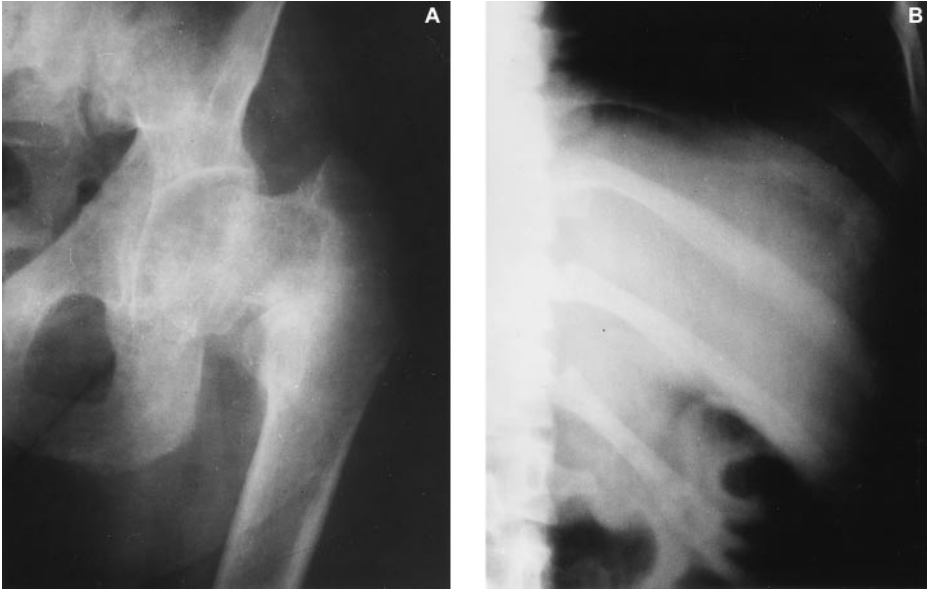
Adult-onset familial vitamin-D resistant hypophosphataemic osteomalacia. X-rays of a fracture of the left hip (A) and pseudofractures of the ribs (B).
